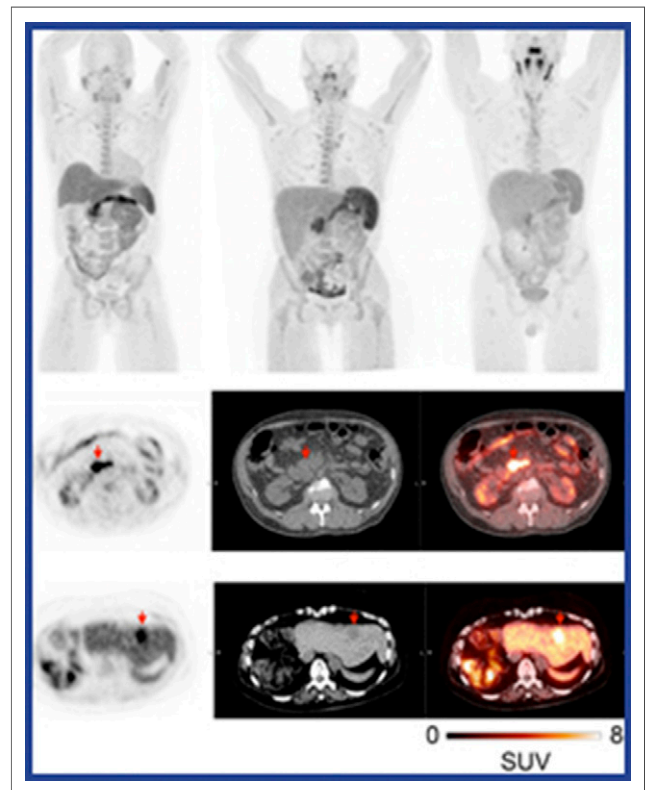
First-in-human images with ^{18}F -FluorThanaTrace (^{18}F -TFT), a PARP-targeted PET tracer. Top row: PET images acquired at 30, 120, and 210 minutes after injection in 3 healthy volunteers. Middle row: ^{18}F -TFT PET, CT and fused transaxial images in a 52-year-old man with recurrent pancreatic cancer. Bottom row: transaxial PET, CT and fused images of a 62-year-old woman with metastatic biphenotypic hepatocellular carcinoma/choleangioma.
